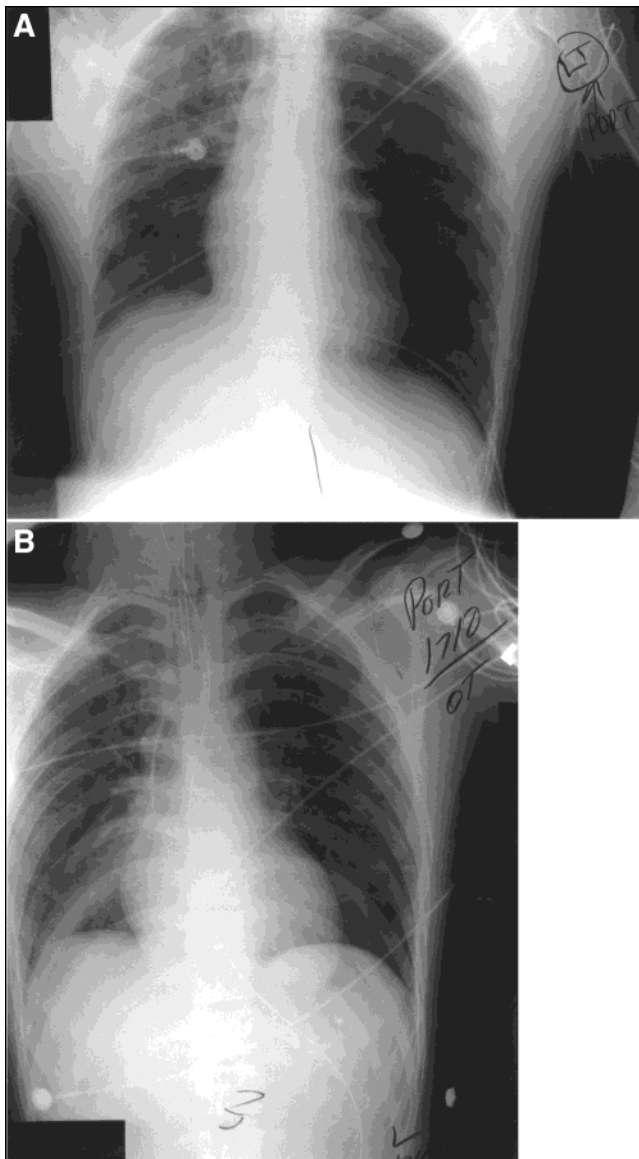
(A) The chest radiograph soon after admission shows a normally placed endotracheal tube and a patchy opacity in the right lung suggesting a pulmonary contusion. (B) The second chest radiograph obtained 12 h later shows an infiltration of the right lung with atelectasis of the right lower lobe and a small pneumothorax in the left lung.
